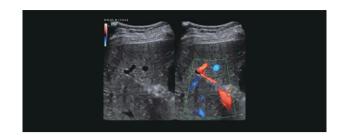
A dilated PV and an increased diameter HA and HA branches, visualized by the Color Doppler feature combined with Glazing Flow and the cUMA, pUMA, and sUMA sub-modes.
